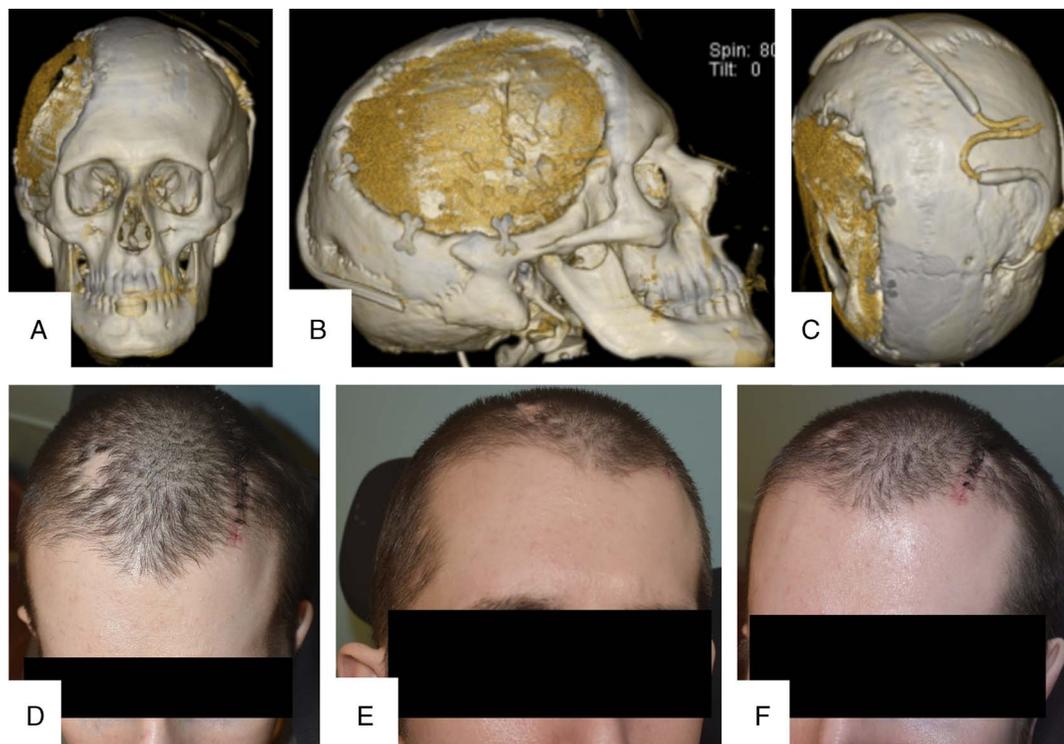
Postoperative images of 2-stage cranioplasty case demonstrated in Figure 3. A–C, Coronal, lateral and horizontal views of 3D reconstructed CT scan showing cranial implant. The hydrocephalus shunt and 2 postoperative drains are seen. D–F, Postoperative photographs of patient at 1 month just before suture removal. Note symmetric cranial contour and healing incisions.
